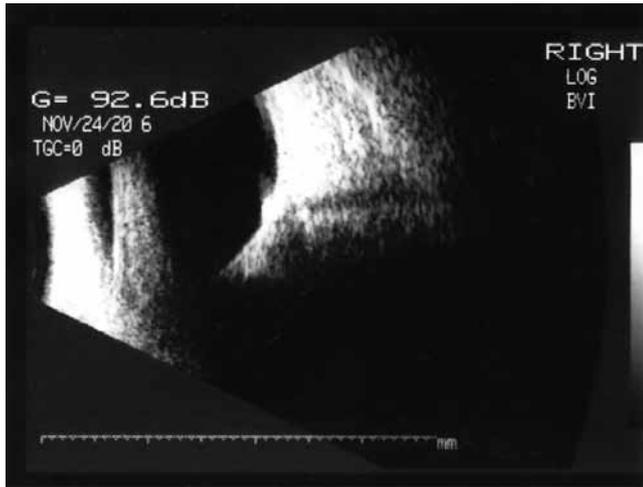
Ultrasonogram of the right eye: optic disc drusen.
